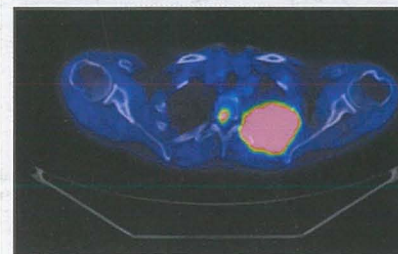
Superimposed PET-CT image showing both the lung and bone lesion in one scan.
